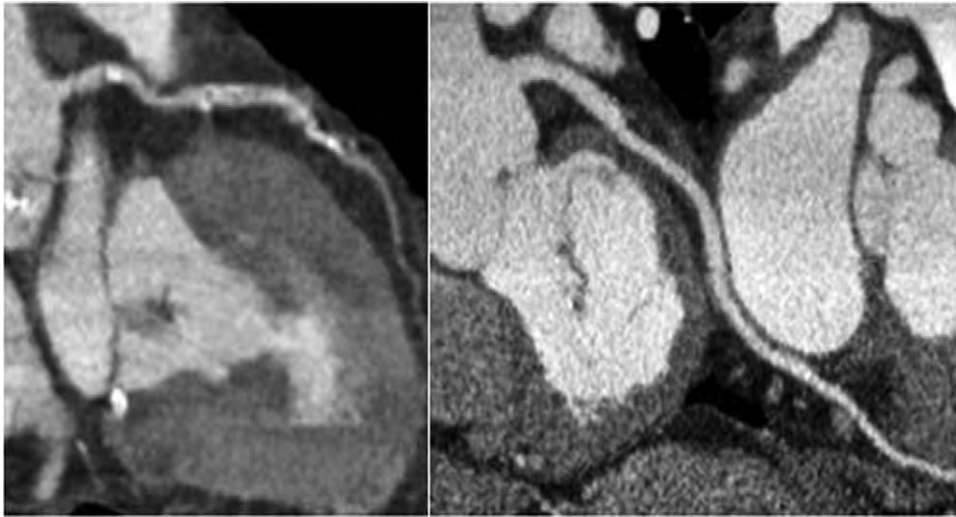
In this case example of CTA, the left anterior descending is diffusely diseased on the left panel and the obtuse marginal branch is normal (right panel).
